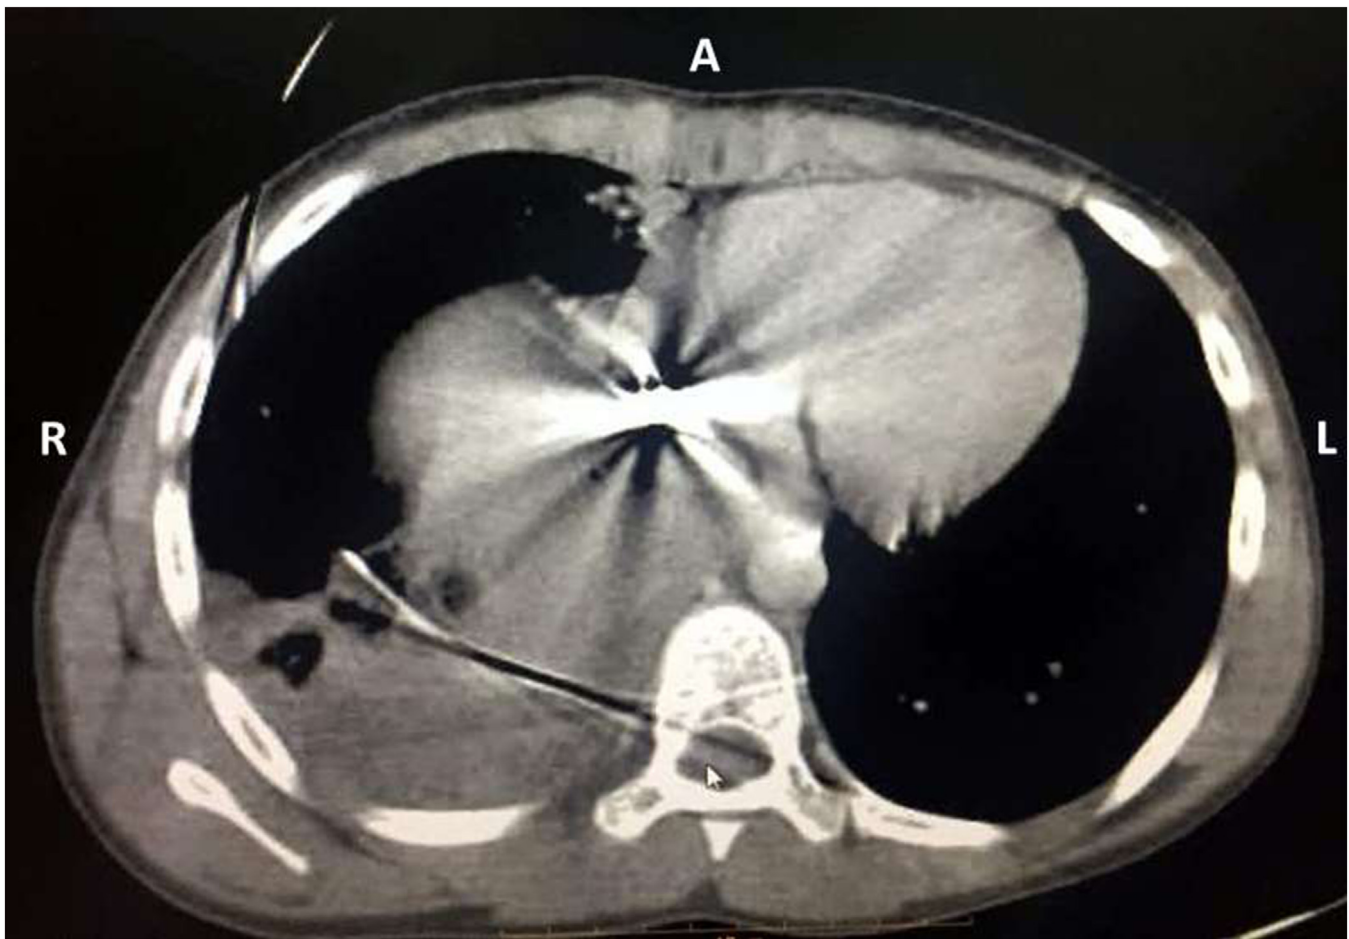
Chest CT demonstrating the more accurate position of the bullet with its high-density foreign material artifact, haemothorax, the atelectasis of the inferior lobe of the right lung, and an accurately positioned chest tube.
